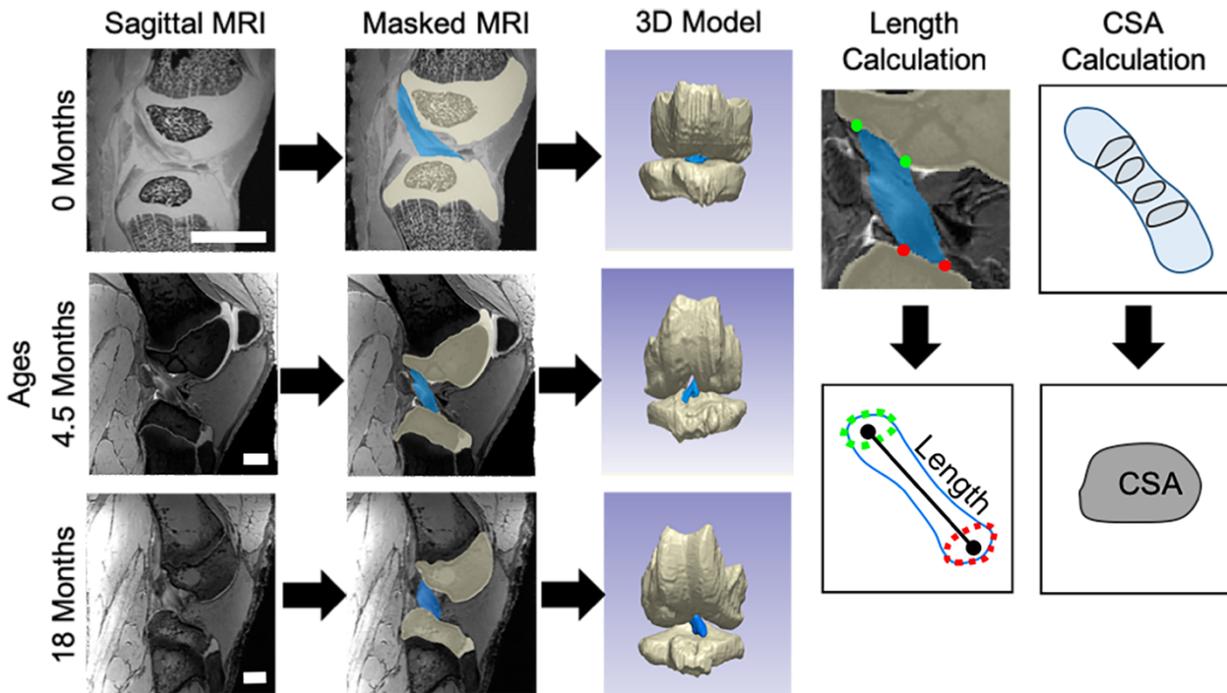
3D models were created for tissues such as the anterior cruciate ligament (ACL) using MRI scans and segmentations of individual tissues. Images shown for newborn (0 month), early adolescent (4.5 month), and late adolescent (18 month) joints, scale bars are 10 mm. Length and cross-sectional area (CSA) calculation methods described for an ACL.
